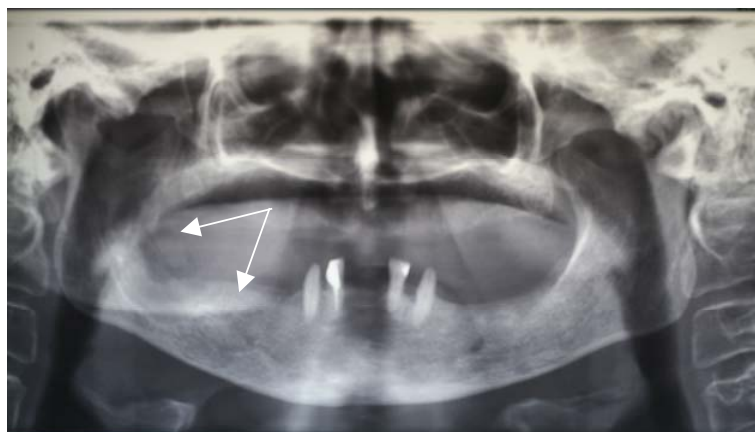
The orthopantomographic radiography six months after the second surgery (arrows).
